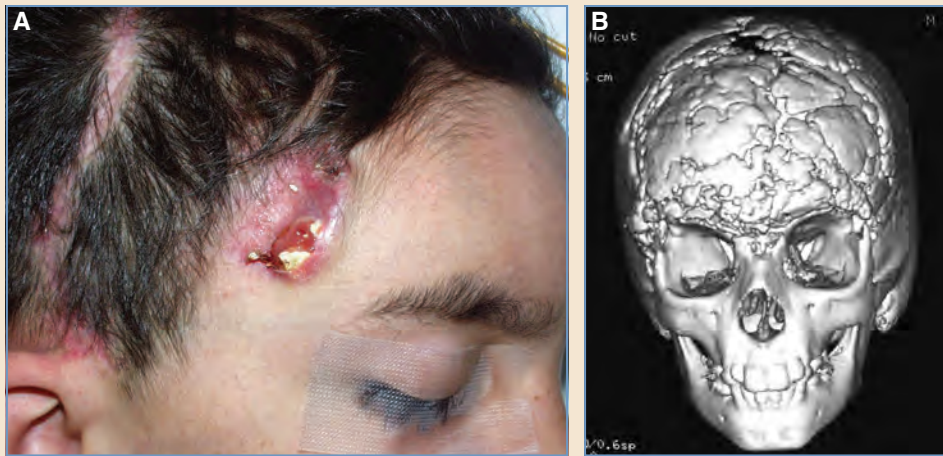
A, An infected bone substitute extruding through the temporal wound. B, A three-dimensional CT scan showing the fractured, infected, and extruding bone substitute.
